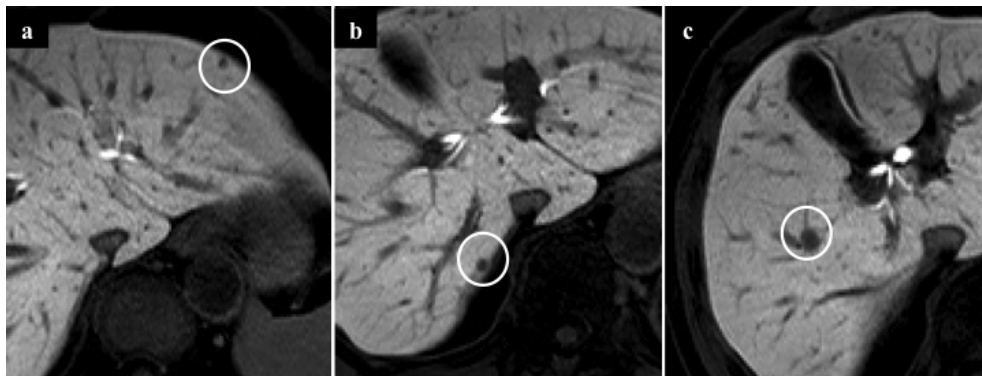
Gadoxetic acid-enhanced magnetic resonance imaging (MRI) of the liver.
